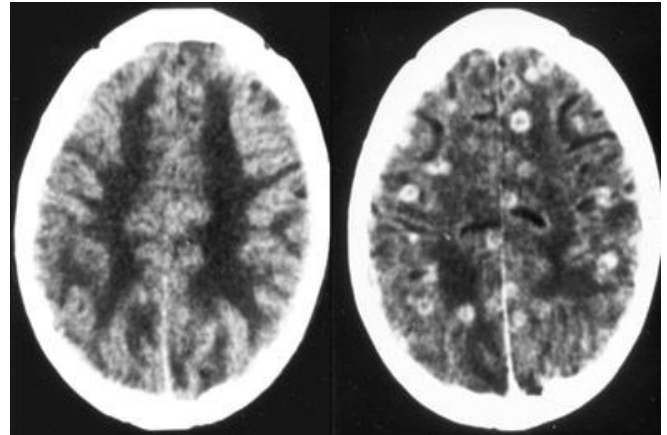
CT scan showing multiple lesion neurocysticercosis
